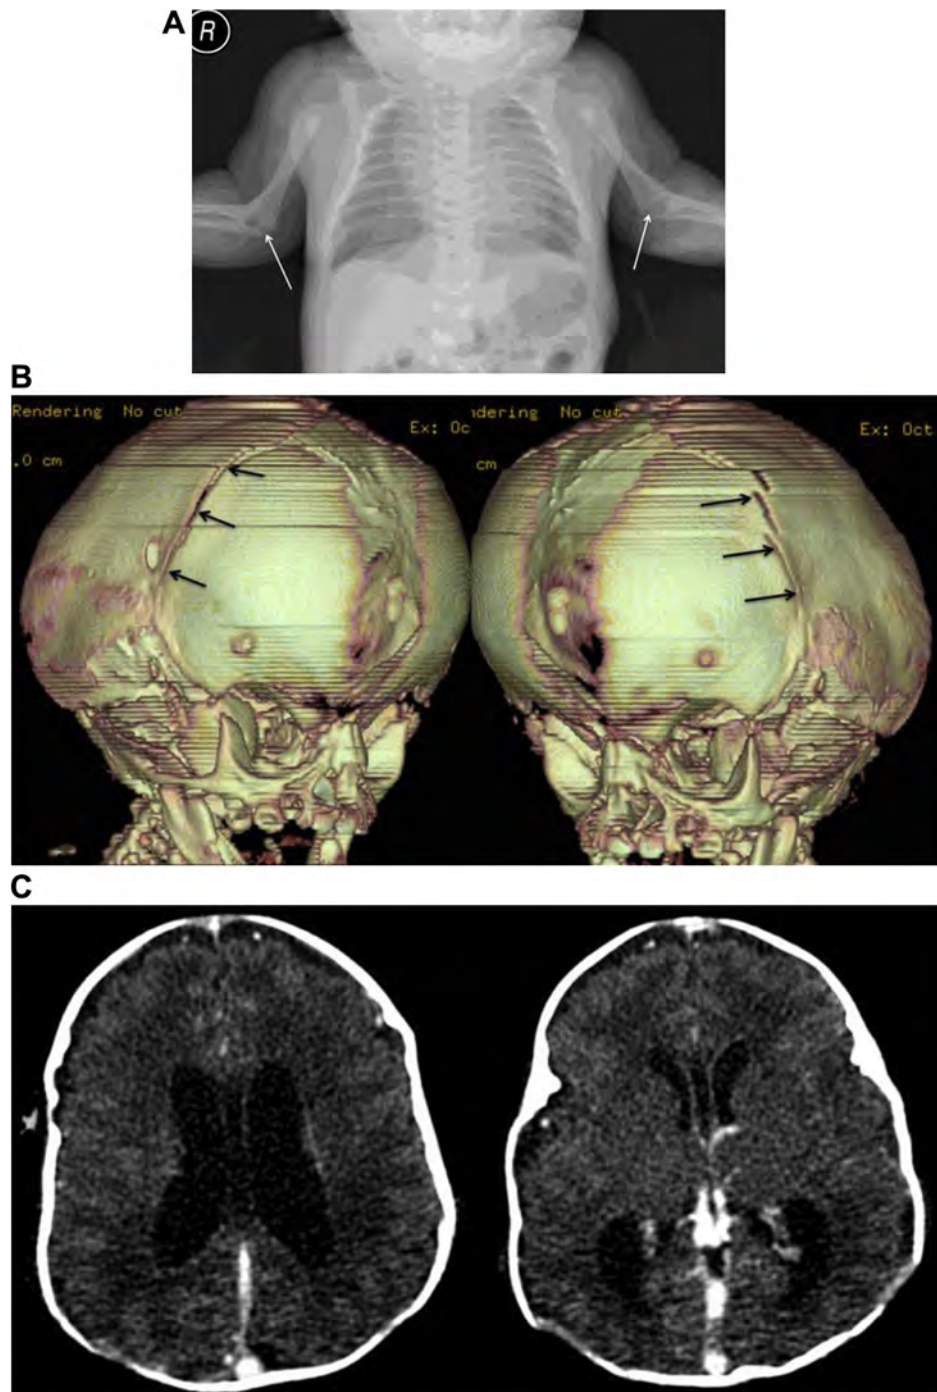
Radiographs show (A) radio–ulnar–humeral synostosis (white arrows); (B) multisynostoses of sagittal and coronal sutures (black arrows), shallow orbits, and brachycephaly; and (C) ventriculomegaly.
